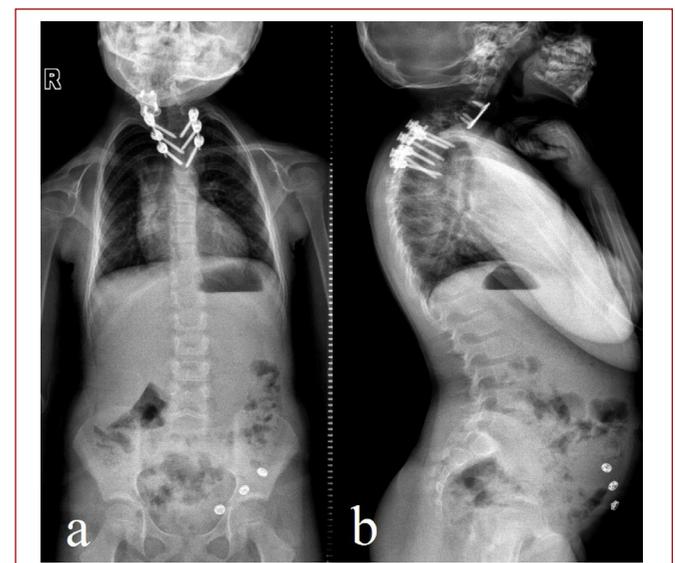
a) Anteroposterior X-ray 5 months after the operation, b) Preoperative lateral X-ray
